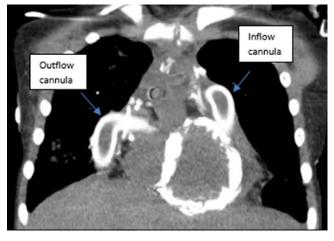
Coronal plane CT scan showing diffuse left ventricular wall calcification and both left atrial outflow and aortic inflow cannulae in position. CT, computerized tomography.
